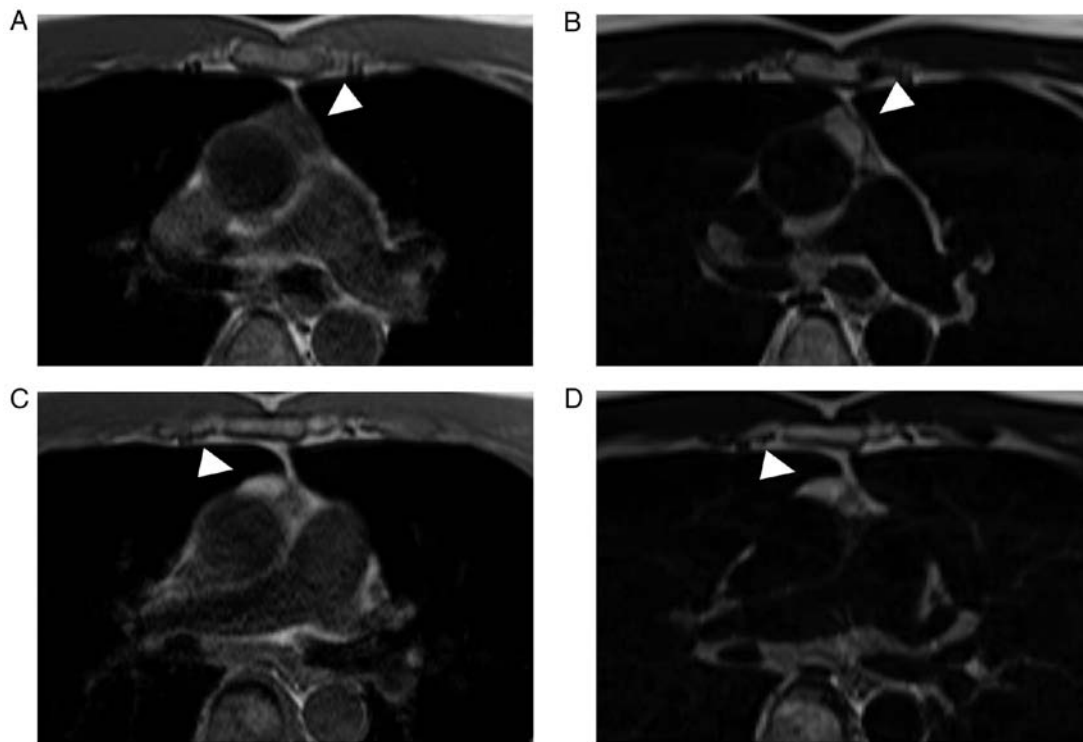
Magnetic resonance images showing a 28-mm bilocular cyst (white arrow). One of the two chambers shows (A) low intensity on T1-weighted images and (B) high intensity on T2-weighted images, whereas the other chamber shows high intensity on both (C) T1-weighted and (D) T2-weighted images.
